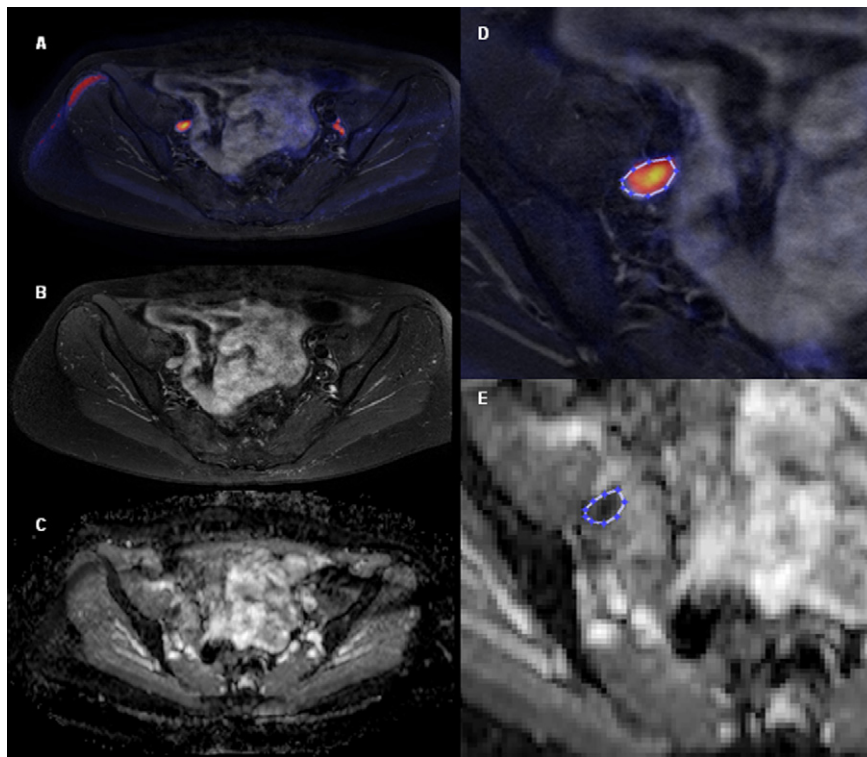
A) Axial T2-weighted SPAIR, fused with DWI ( $b = 1000 \text{ s/mm}^2$ ). Para-iliac lymph nodes are highlighted and easier to detect. (B) Axial T2-weighted SPAIR without the fusion image. (C) Apparent diffusion coefficient (ADC) map of this slice. (D) ADC measurement of the highlighted lymph node: a manually placed region of interest (ROI). (E) The ROI is then copied to the ADC map and manually adjusted if necessary.
